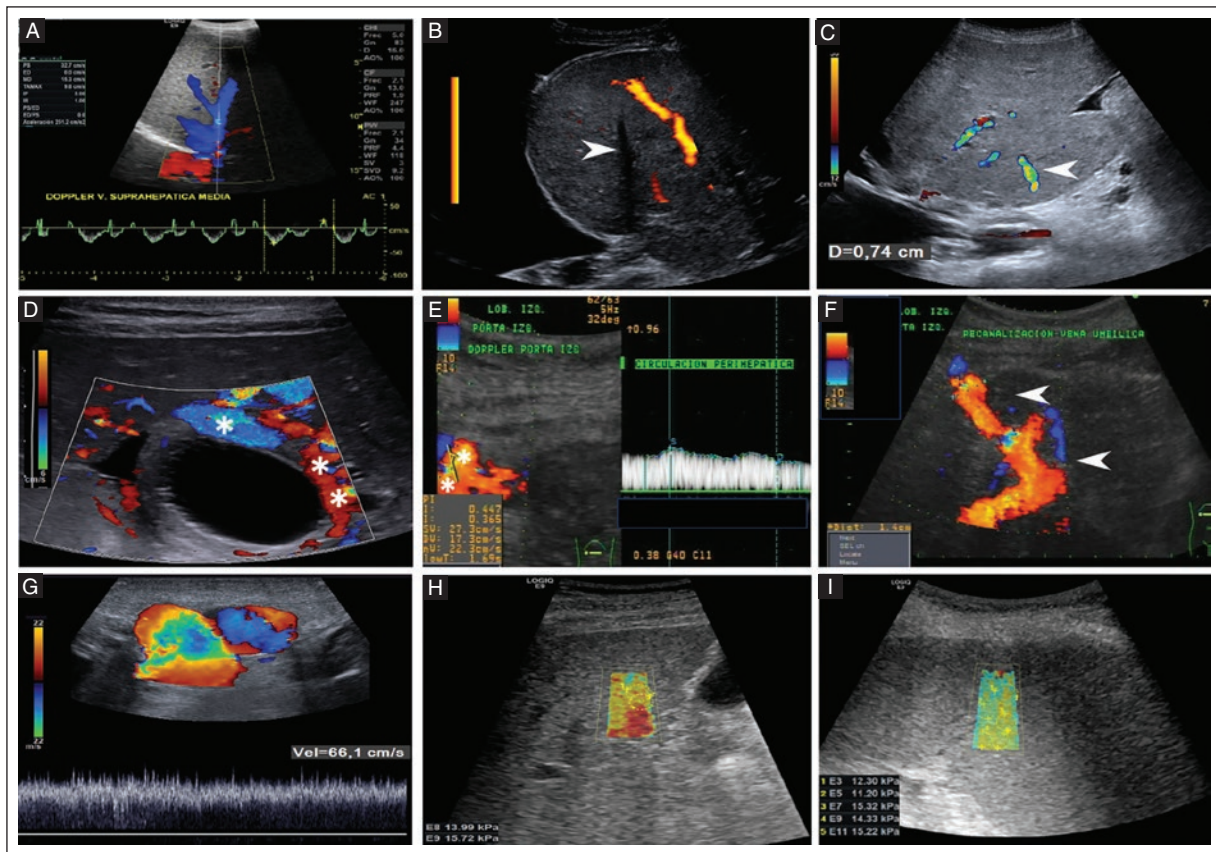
Hemodynamic US duplex findings of the hepatic region in portal hypertension assessment. A: a 32-year-old woman patient with US duplex showing the middle hepatic vein with patency, tetraphasic spectral morphology, and normal velocity. B: a 36-year-old woman with chronic Budd-Chiari syndrome; US power Doppler sagittal view of the right hepatic lobe showing the right hepatic vein (white arrowhead) with absent flow, secondary to chronic thrombosis and patency of the right portal vein with hepato-petal flow, with abundant fluid in the right pleural cavity. C: a color Doppler US sagittal view of the left hepatic lobe of the same patient showing severe hypertrophy of the caudate lobe and dilatation of its draining vein (white arrowhead) with a diameter of 7.4 mm (caliper not shown), perihepatic free fluid and in the right pleural cavity. D: a 58-year-old man with alcoholic liver disease. US color Doppler with significant pericholecystic collateral circulation (white asterisks). E: a 69-year-old woman, transverse view with US duplex showing collateral circulation in the wall and perihepatic area due to recanalization of the umbilical vein (asterisks) with a hepato-fugal velocity of 27.3 cm/s. F: a 69-year-old woman with CLD. Color Doppler US transverse view of the left lobe showing a 14 mm dilated vessel along the entire course of the falciform ligament in relation to recanalization of the umbilical vein (white arrowheads). G: US duplex with a high-resolution linear transducer in transverse view in the periumbilical region shows a periumbilical collateral circulation with dilated and tortuous vessels of 2.2 cm caliber (not shown) with severe hepatofugal flow with a velocity of 66.1 cm/s. H: a 69-year-old man with alcoholic liver disease. Oblique view with intercostal approach of the right hepatic lobe over segment V using ARFI elastography with two determinations of 13.9 and 15.7 kPa; the median after 12 determinations (not shown) was 12.2 kPa. Metavir score F4 = cirrhosis. I: a 72-year-old woman with CLD. A transverse approach to the spleen with ARFI elastography showing five measurements after 12 determinations (not shown) was 12.8 kPa, Metavir score F0 = normal.
